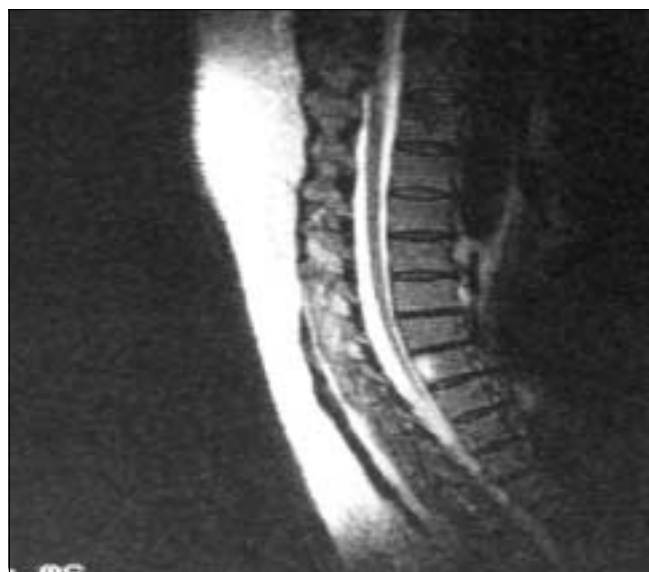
MRI of a normal thoracic spine, T2-weighted sagittal view. Comparing the normal spinal image to the pathologic one, no increased signal of the spinal cord nor flow voids are seen.
